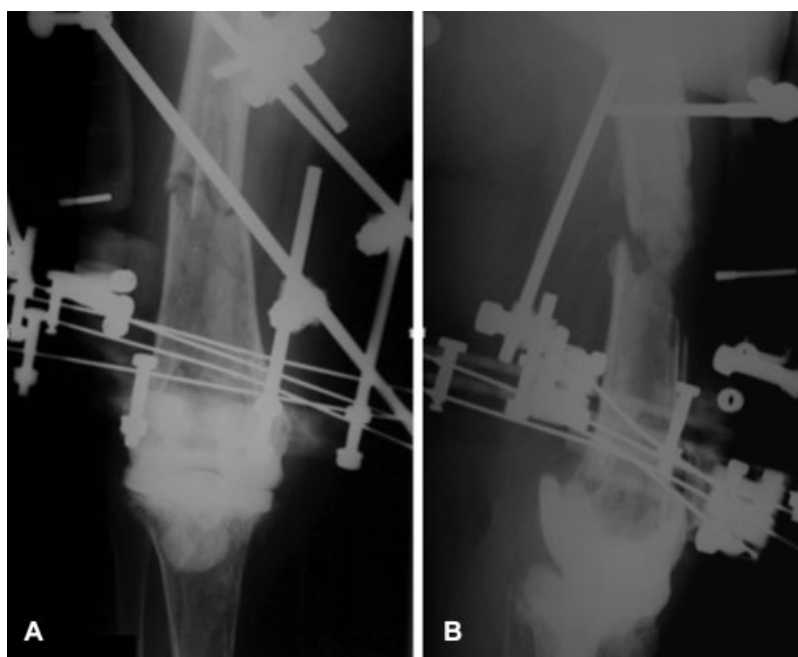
Anteroposterior (A) and lateral (B) X-rays reveal a fracture at third distal of femur and atrophic nonunion.
